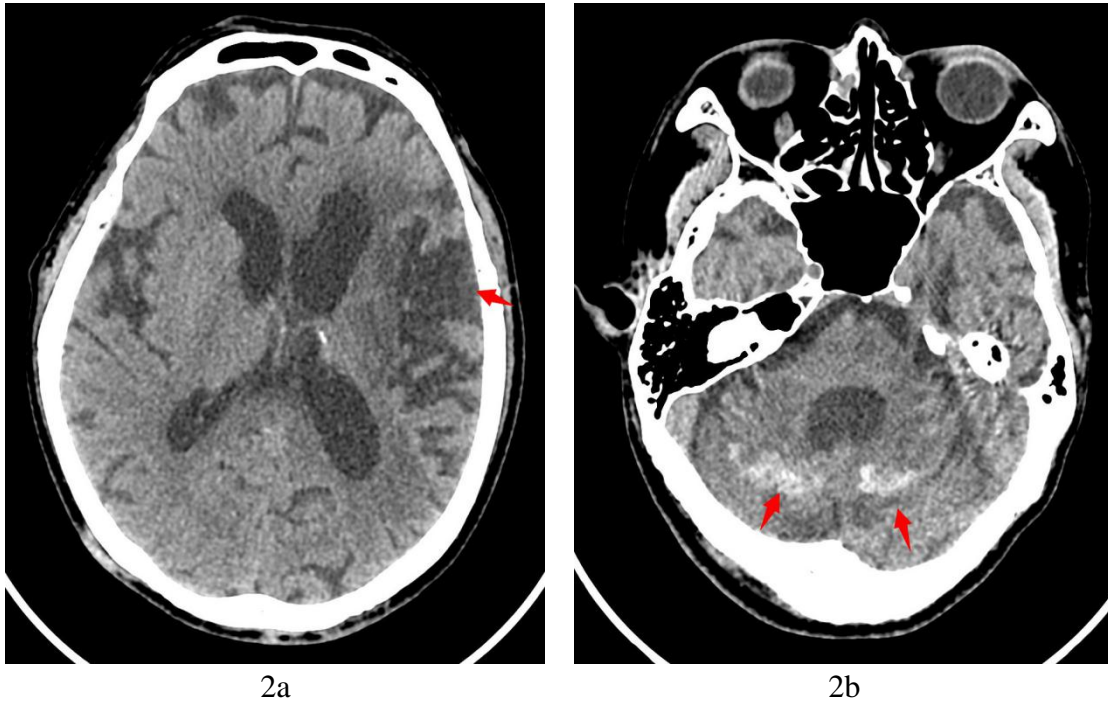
Axial view of non-contrast brain CT. (a) Patchy hypodense images in left temporo-frontal lobes. The ventricles, sulci and extra-axial spaces are slightly dilated. (b) Diffuse symmetrical hyperdensity in cerebellar hemispheres are again noted, and the lateral and 4th ventricles are dilated.
